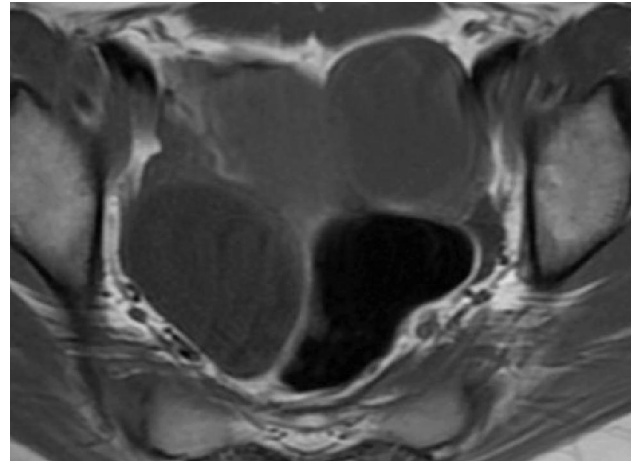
MRI T1 weighted Axial Image: Heterogeneous complex cystic areas are seen in both adnexa with intermediate signal intensity on T1 weighted images representing Hemorrhagic cyst.
